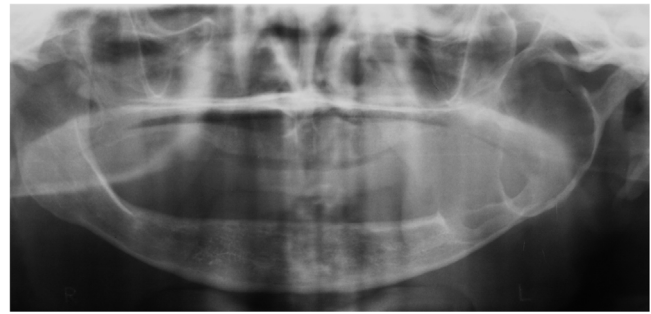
Conventional panoramic radiograph revealing multilocular osteolytic lesion causing destruction of the body and ramus of the mandible.
